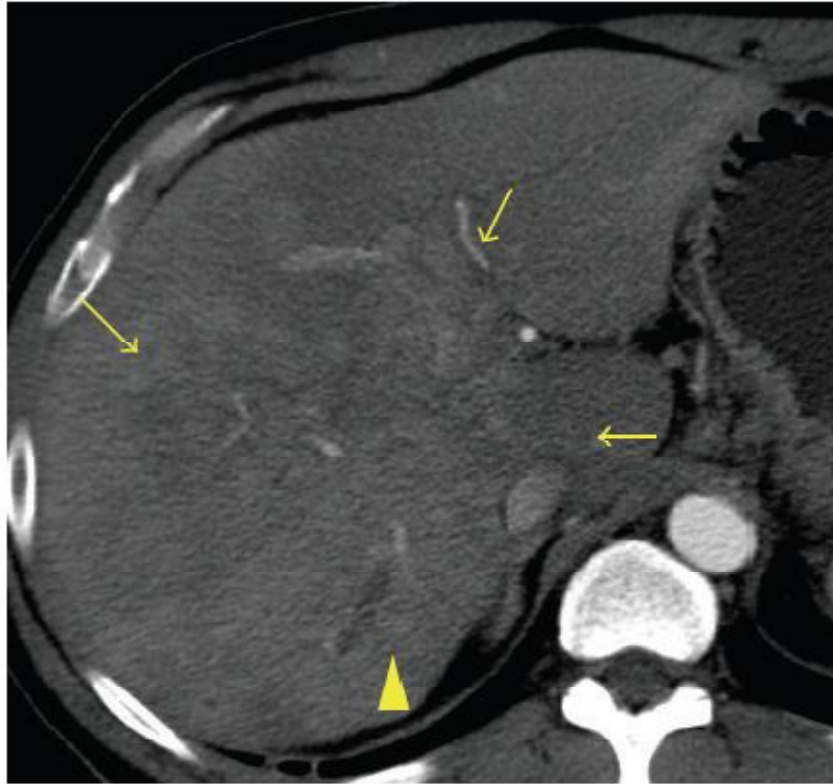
Diffuse hepatocellular carcinoma. Arterial-phase contrast enhanced axial CT scan demonstrates a large ill-defined heterogeneous mass occupying the right hepatic lobe (arrows). Focal intrahepatic biliary dilatation is seen (arrowhead). (www.ajronline.org/27/9/2014 at 5:00pm)
